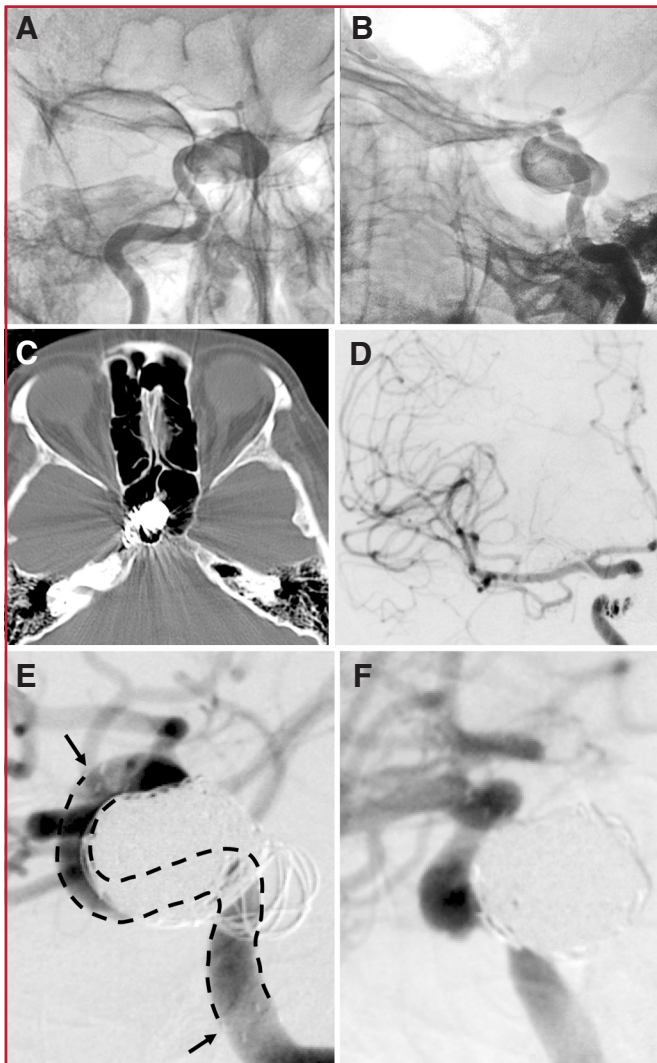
Patient 18. Anteroposterior (A) and lateral (B) unsubtracted angiograms demonstrating erosion of a right cavernous ICA aneurysm into the sphenoid sinus, further highlighted by the location of the coils on the postoperative CT scan (C). Anteroposterior (D) and lateral (E) images showing obliteration of the aneurysm, along with a patent parent vessel. The dotted line marks a segment of the stented carotid artery obscured by the coil mass, whereas the arrows denote proximal and distal stent markers. F, oblique view demonstrating lack of any significant aneurysm neck residual.
